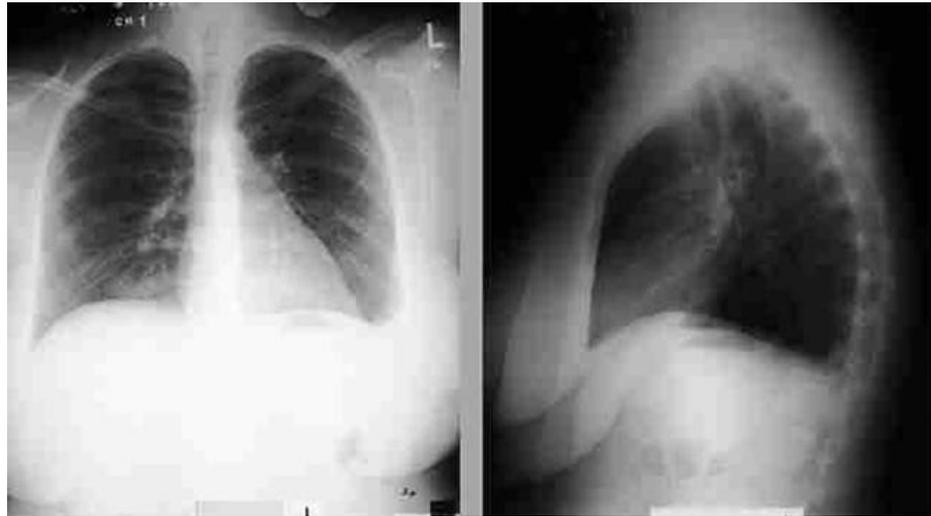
Posteroanterior and lateral chest radiograph findings are normal, which is the usual finding in patients with pulmonary embolism
